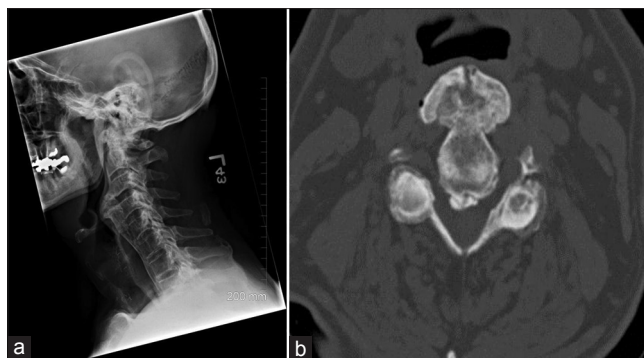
(a) Pre-operative plain radiograph of the neck showing anterior cervical osteophytes at the level of the epiglottis, (b) Pre-operative computerized tomogram showing the anterior cervical osteophyte at the level of the epiglottis with size equal to that of vertebral body
